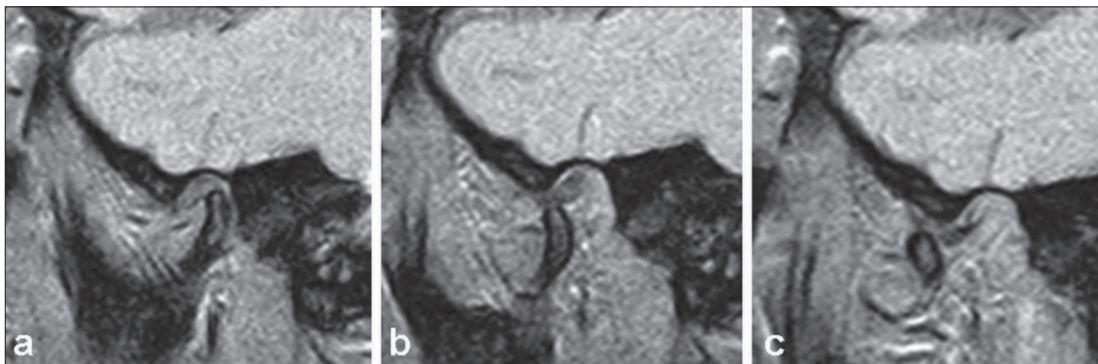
Parasagittal magnetic resonance images of the temporomandibular joint in the closed jaw (a), semiopened jaw (b), and fully opened jaw (c) positions with the use of the applicator; the translation of the mandibular condyle and the disc movements can be observed in the 12 o'clock position
